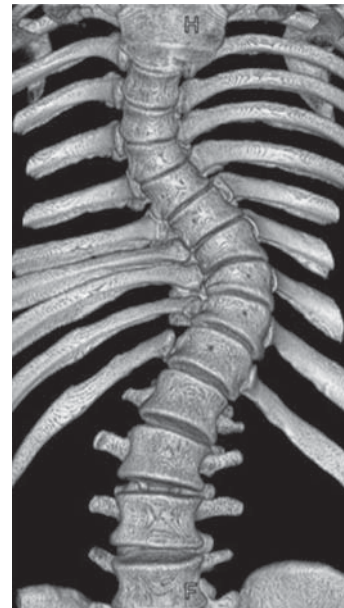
Three-dimensional computed tomography reveals a wedge deformity of the vertebral body, although the rotational deformity was mild.
